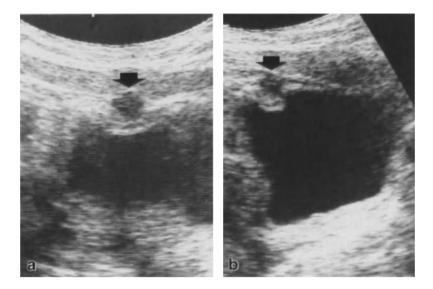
a,b. Urachal remnant. a Transverse ultrasound scan demonstrates urachal remnant (*arrow*) in the midline. b Sagittal scan demonstrates that the urachal remnant (*arrow*) is anterosuperior to the bladder. (CACCIARELLI et al. 1990)
